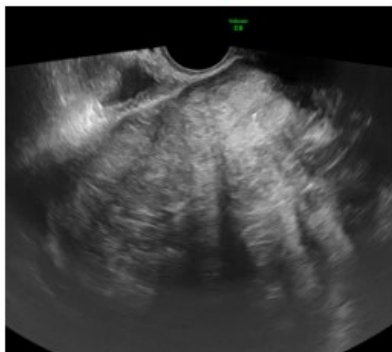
Ultrasound image: pronounced myometrial edema and unclear contours of the nodes.
